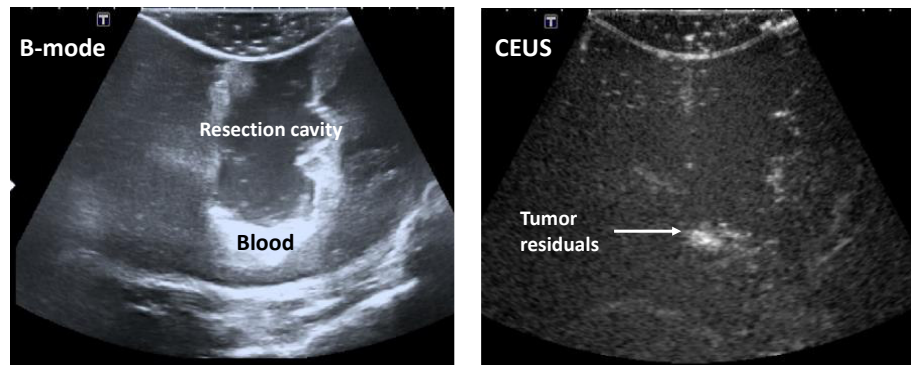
Intraoperative B-mode ultrasound (iB-mode) (left) and iCEUS (contrast enhanced ultrasound (CEUS)) (right) patient image data acquired at the end of a brain tumor operation.
